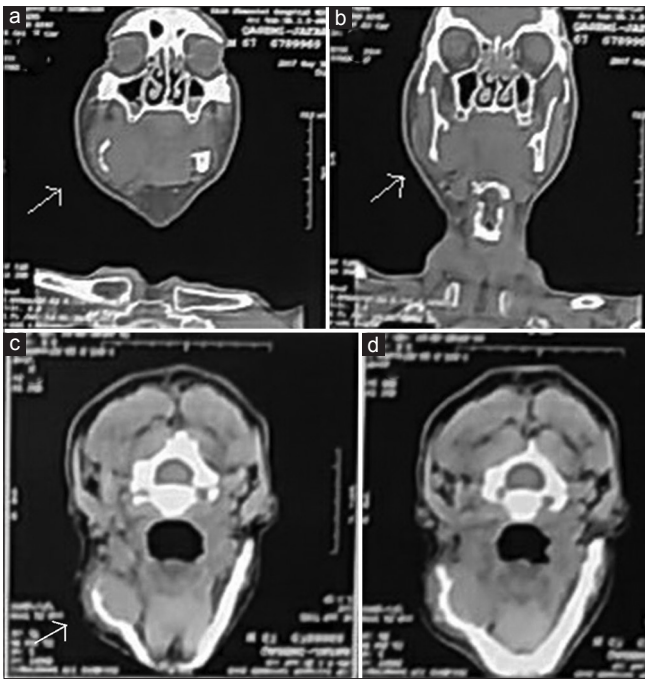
Computed tomography without contrast. Oblique coronal view shows perforation of inferior and lingual mandibular border (a and b). Axial view shows buccal and lingual cortex expansion (c and d)
